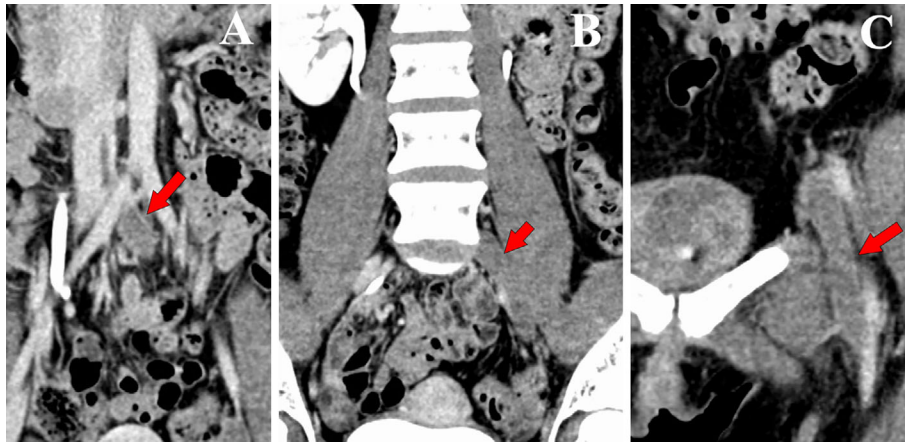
Poor contrast from the inferior vena cava (A) to the left femoral vein (B, C) on contrast-enhanced computed tomography (CECT) (indicated by red arrows).
